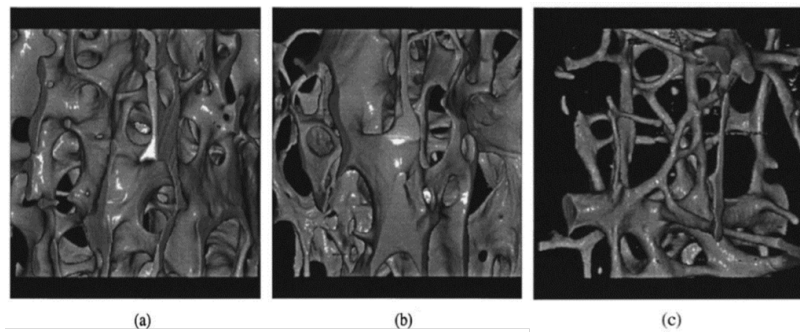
3D reconstructions of human vertebrae using SR- $\mu$ CT. (a) 33 year old female; (b) 55 year old female; (c) 72 year old female (Salomé et al., 1999).
